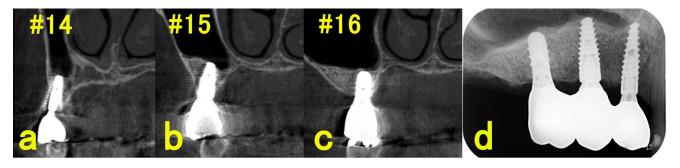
Two years and 3 months after sinus elevation and 1 year and 3 months after the placement of the prosthetic structure, crosssectional CBCT images of the 3 implant sites are as follows: (a) #14 (b) #15 (c) #16. (d) Periapical X-ray image at that time.
